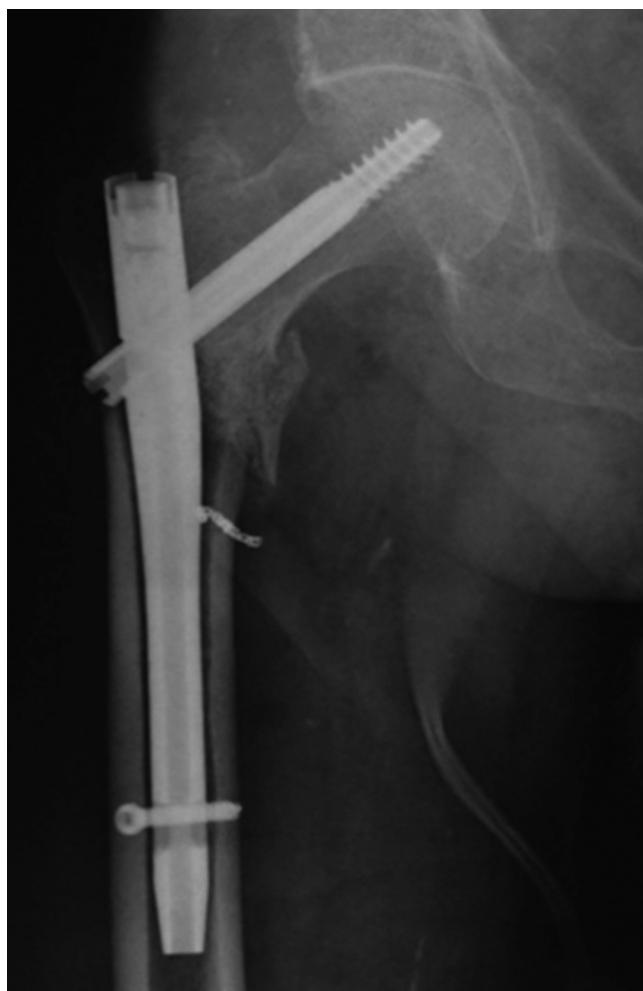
Six months after the operation, the X-rays of the hip showed complete healing of the fracture. The endovascular device was quite visible below the lesser trochanter.
